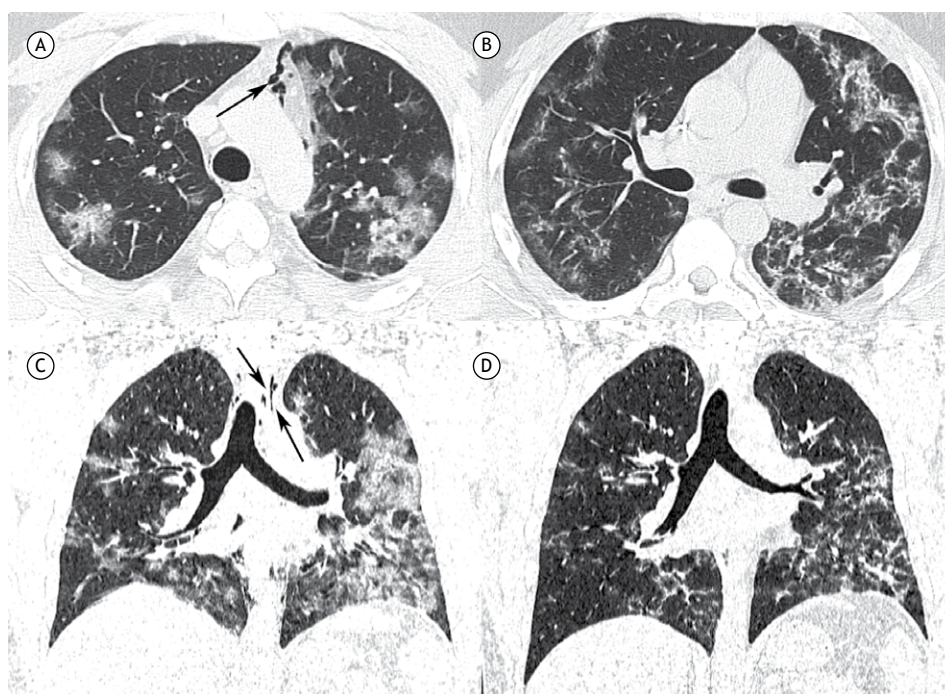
Axial (A and B) and coronal (C) unenhanced CT scans of the chest showing ground-glass opacities in both lungs. Note the presence of pneumomediastinum (arrows). A reconstructed coronal image obtained four days later (D) demonstrated improvement in the areas of ground-glass opacity and resorption of the pneumomediastinum.
